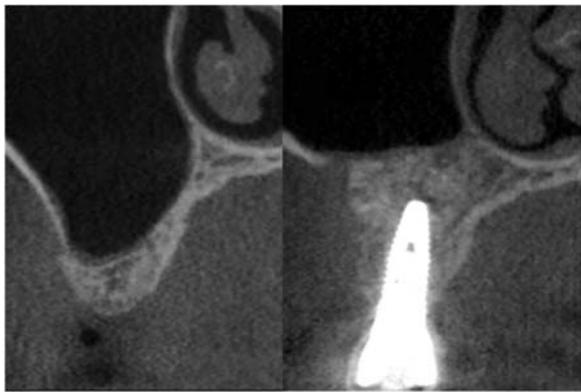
Preoperative and postoperative CBCT.
